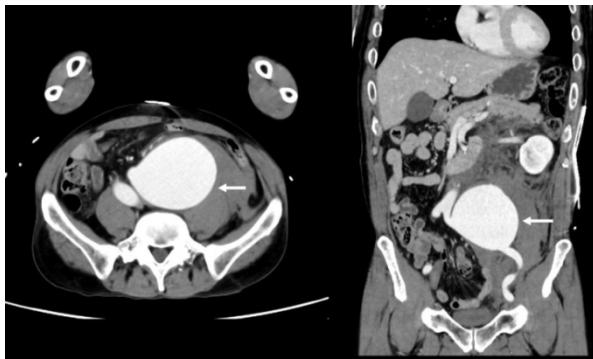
Enhanced truncal computed tomography (CT) on arrival (left, axial and right, coronal image)
